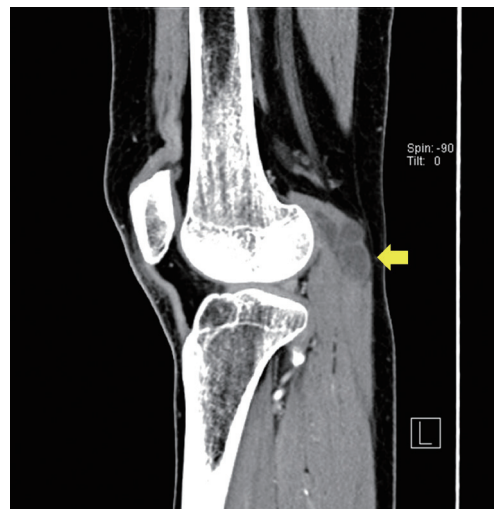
Preoperative computed tomography scan shows a multi-lobulated hypodense lesion, measuring approximately 5 cm × 3 cm, within the proximal lateral gastrocnemius muscle (yellow arrow).
